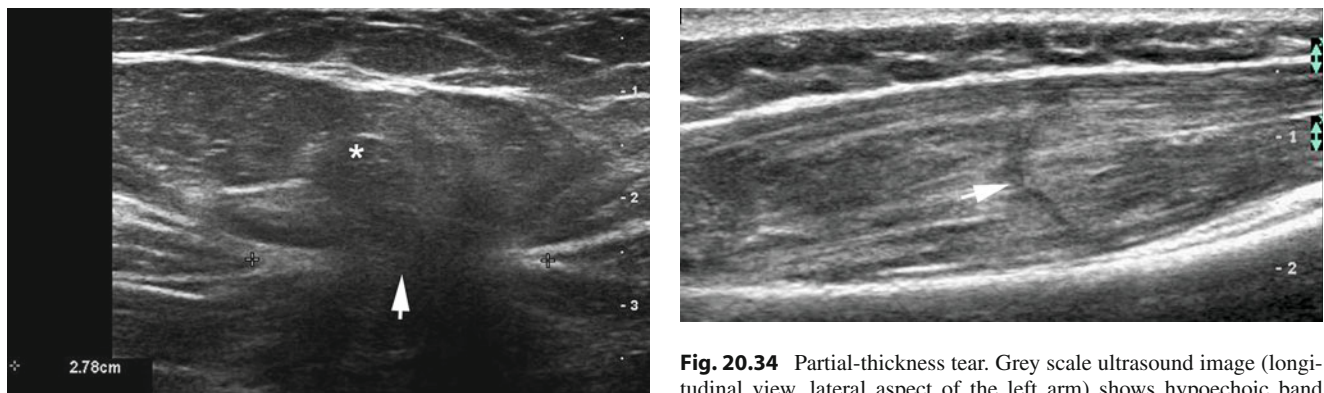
Abdominal wall hernia. Grey scale ultrasound image (transverse view) demonstrates a herniation of fatty tissue (*) through a defect (arrow) in the aponeurosis. There is a 2.78 cm (wide) diastasis (between markers) of the bellies of the rectus abdominis muscles
